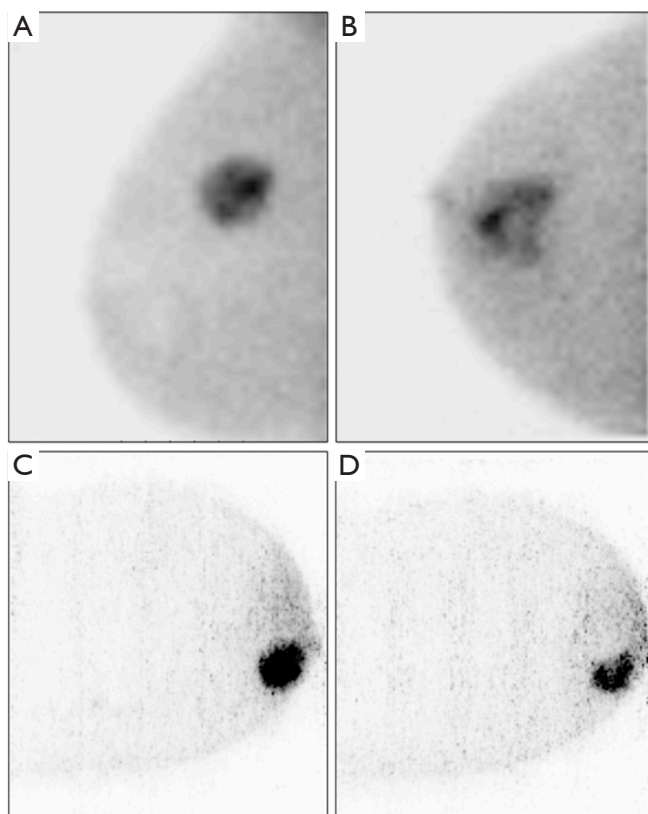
Heterogeneous uptake of ^{99m}Tc -MIBI in invasive ductal breast carcinoma with a 3-cm lesion (A) and a 5-cm lesion (B) as shown using breast-specific gamma imaging. In another patient, heterogeneous uptake of ^{18}F -FDG is seen after the first cycle of neoadjuvant chemotherapy in the superior part of the lesion (D), which was homogenous at baseline acquisition (C) with a dedicated hanging breast PET scanner. ^{18}F -FDG, ^{18}F -fluorodeoxyglucose; PET, positron emission tomography.
